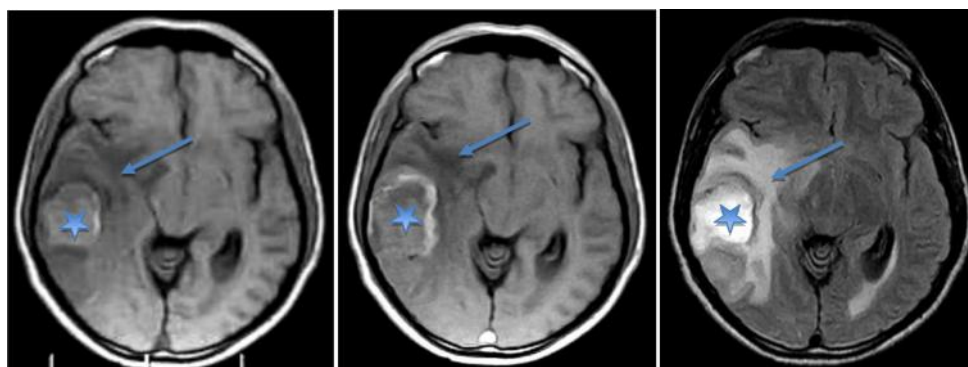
Precontrast, post-contrast T1W and FLAIR axial images of a known GBM patient showing a slightly hyperintense mass in the right temporal lobe (star), showing rim enhancement and extensive peri-lesional edema (arrow).
